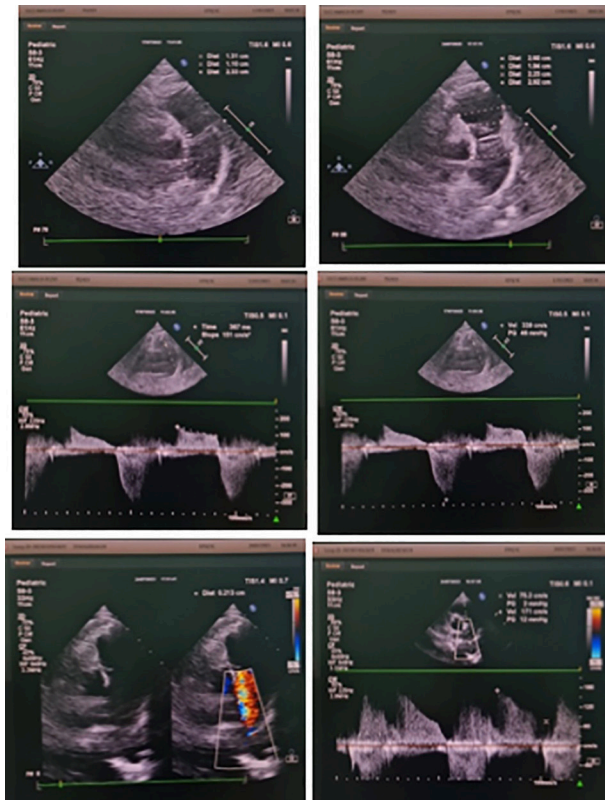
Echocardiography findings of the patient.
